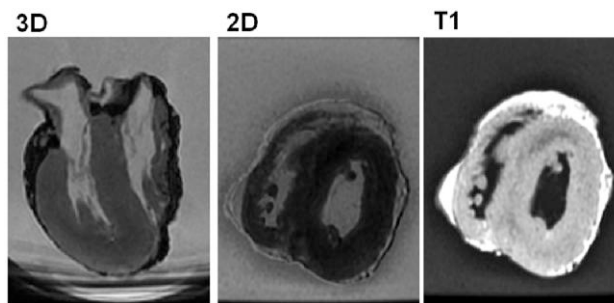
Post-mortem cardiac MRI images. Four-chamber view (left) and short-axis view (centre); steady state free precession (SSFP) acquisition; increased T1 signal in the mid-wall portion of the anterior septum (right).
